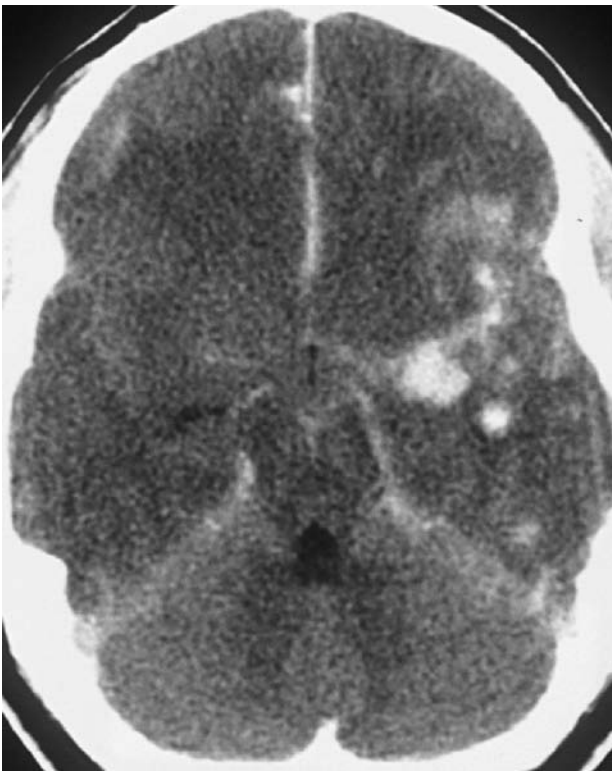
Cerebral contusion. This 16-year-old adolescent girl was comatose after being a passenger in a high-speed motor vehicle collision. A head computed tomographic scan shows hemorrhagic contusion of the left temporal lobe, subdural hematoma along the tentorial margins, and effacement of the sulci throughout. The patient died despite intensive medical management for increased intracranial pressure.
